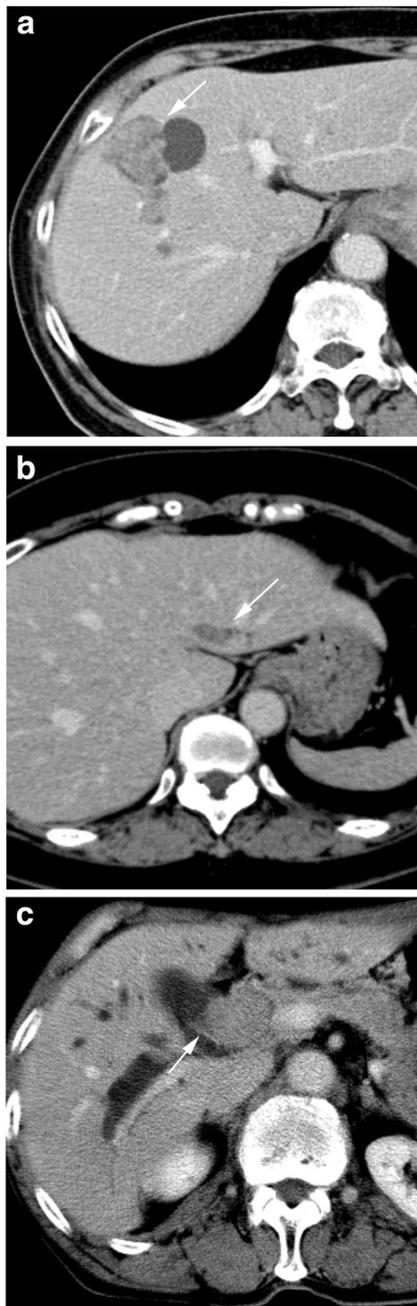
Representative images of cyst-forming IPNB (a), cast-like-type IPNB (b), and PCC (c). a Contrast-enhanced CT image in a 73-year-old woman shows cystic dilatation of the affected duct accompanied with frond-like nodule (arrow). b Contrast-enhanced CT image of a 62-year-old woman demonstrates frond-like nodule in the left intrahepatic bile duct without cystic dilatation (arrow). c Contrast-enhanced CT image of a 60-year-old man. Abnormal bile duct enhancement is revealed adjacent to the papillary nodule in the distal bile duct (arrow). The upstream bile duct is extremely dilated
